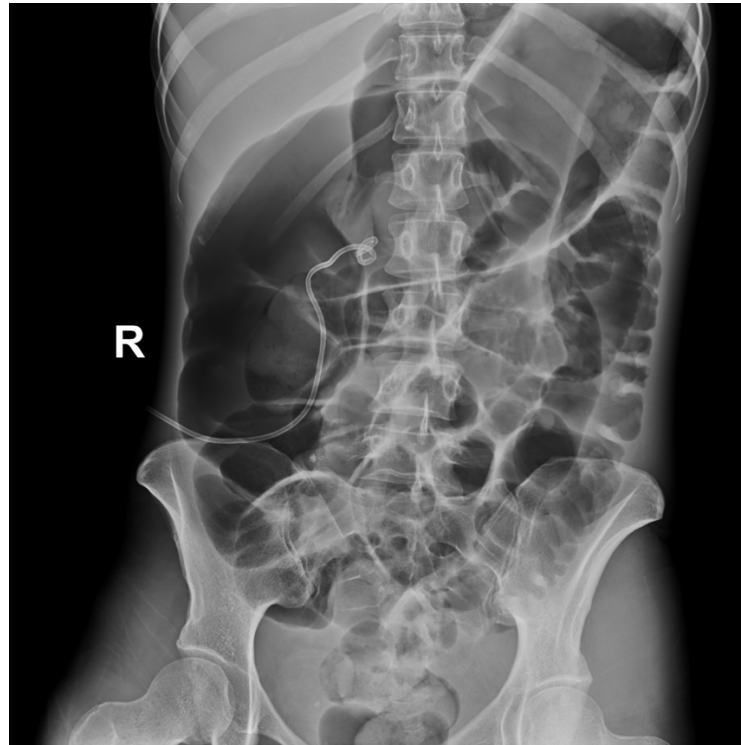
Abdominal X-ray with marked cecal dilation, consistent with Ogilvie Syndrome
